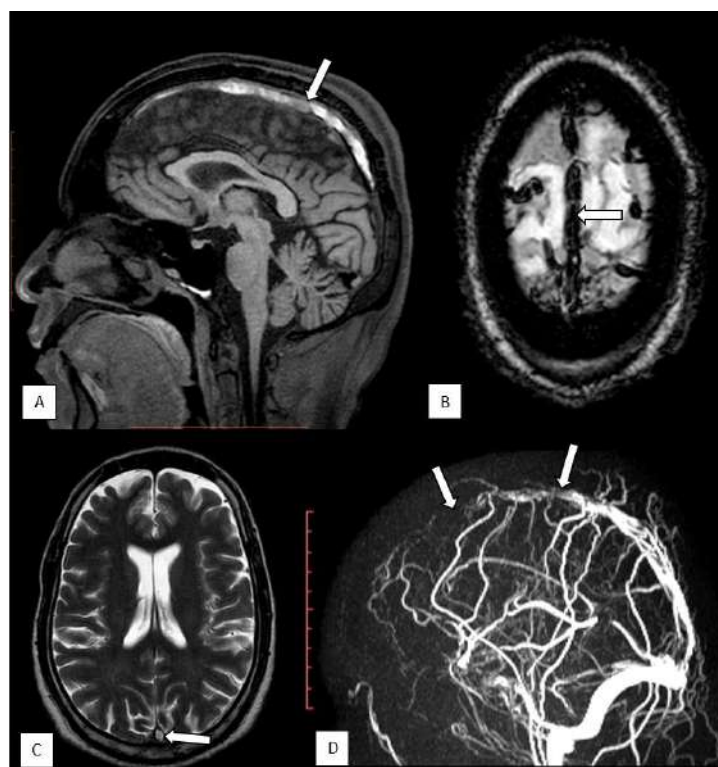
Non enhanced MRI with pulse sequences images acquired at selective sections in a case of 25 year old female patient presenting with post partum seizure. Non enhanced MRI with pulse sequences images acquired at selective sections through the cerebral venous sinuses showing sagittal 3D T1FFE (A) hyperintense signal intensity of the superior sagittal sinus, axial SWI (B) showing blooming, axial T2TSE (C) loss of normal flow void & 3D MIP MRV (D) partial absence of flow signal involving superior sagittal sinus with adjacent collaterals with focal loss of signal in the straight sinus near the confluence of vein of Galen suggestive of superior sagittal sinus thrombosis as depicted by white arrows.
